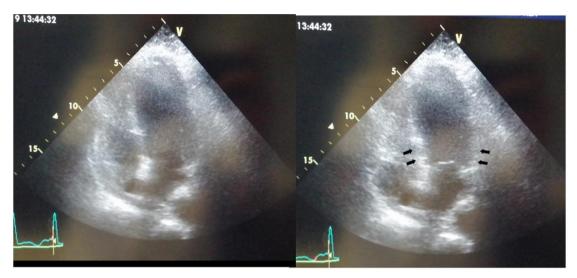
Trans-thoracic echocardiography performed at the second day of admission showing an apical ballooning aspect due to the lost of apical and middle segments wall motions.
